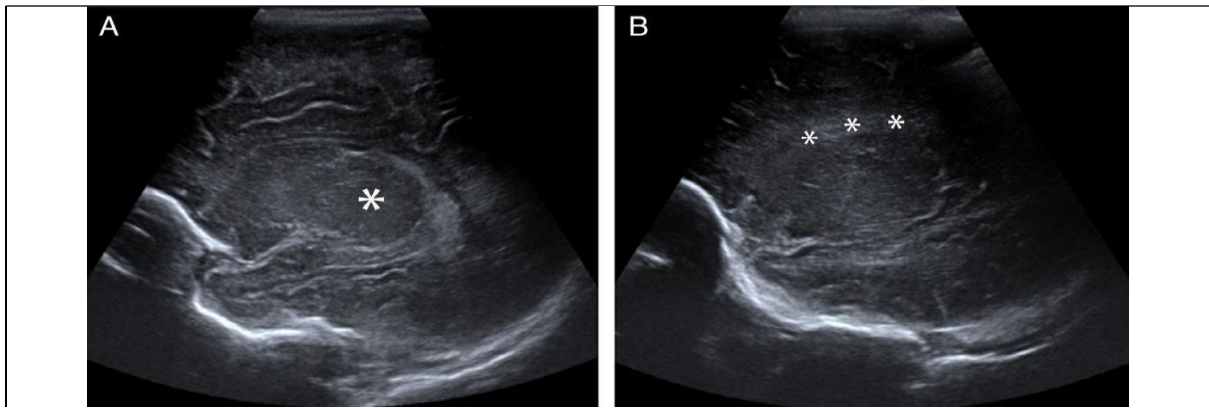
B-mode ultrasound images of the neonatal brain in sagittal perspective. Asterisks designate which shows thalamus (A) & frontal corona radiata (B) as the elastography target locations.
